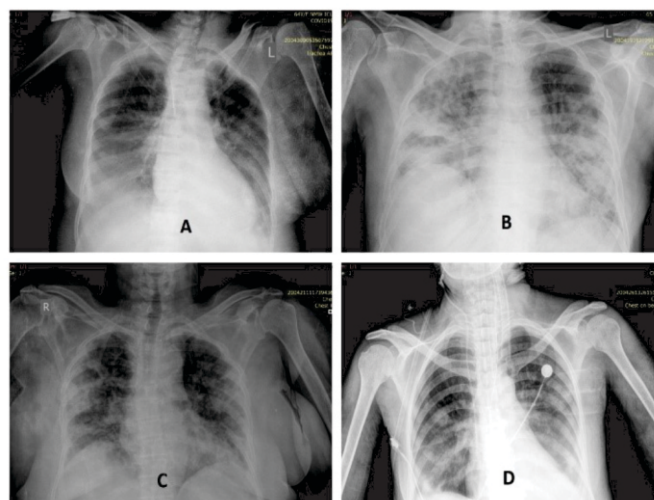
Chest radiographs of critical patients: a - bilateral lower zone ground glass haze , b - diffuse opacification of bilateral lung fields, c - bilateral peripheral consolidations, d - left lower zone ground glass haze + right random opacities.
